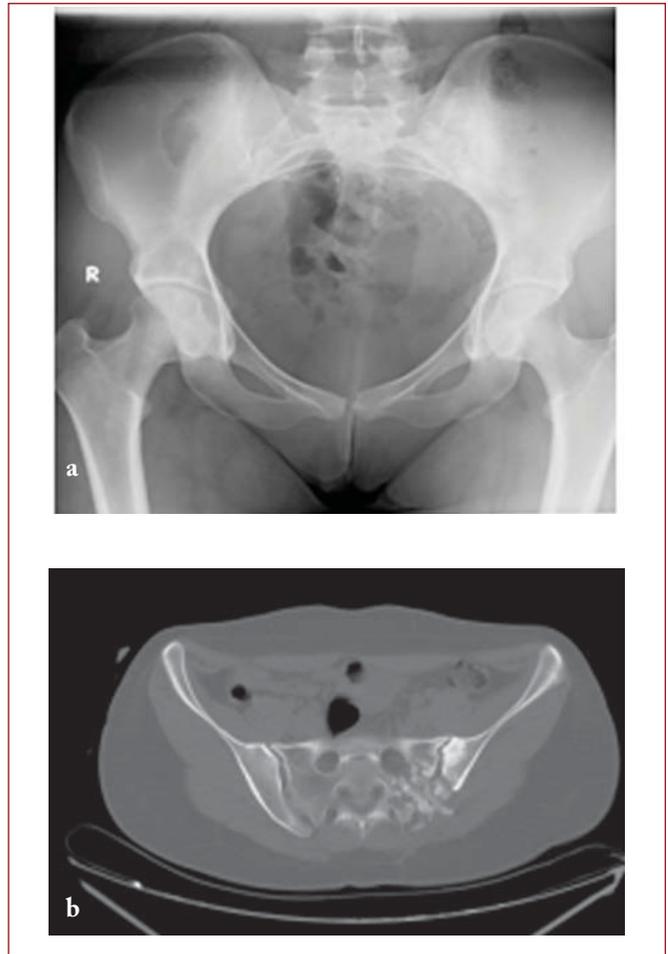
a. Plain pelvic radiograph 11 months after surgery. b. Computerized tomography (CT) scan showing the bone grafts are not yet completely reorganized in the left sacroiliac joint and sacrum. There are erosive changes and sclerosis in the left sacroiliac joint.
